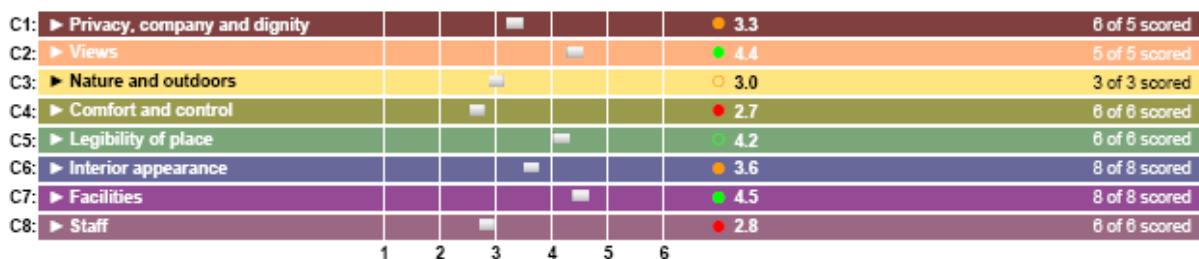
ASPECT example output from the Microsoft Excel spreadsheet version (NHS Estates, 2005)
